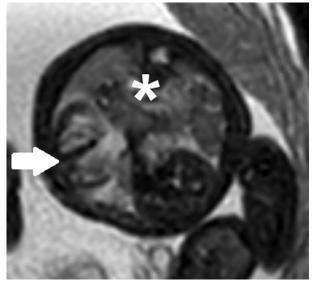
Fetal MRI showing displacement of the intestines (white asterisk) to the right part of the chest and a shift of the heart (white arrow) to the left (radiologist: Dobromiła Barańska)
